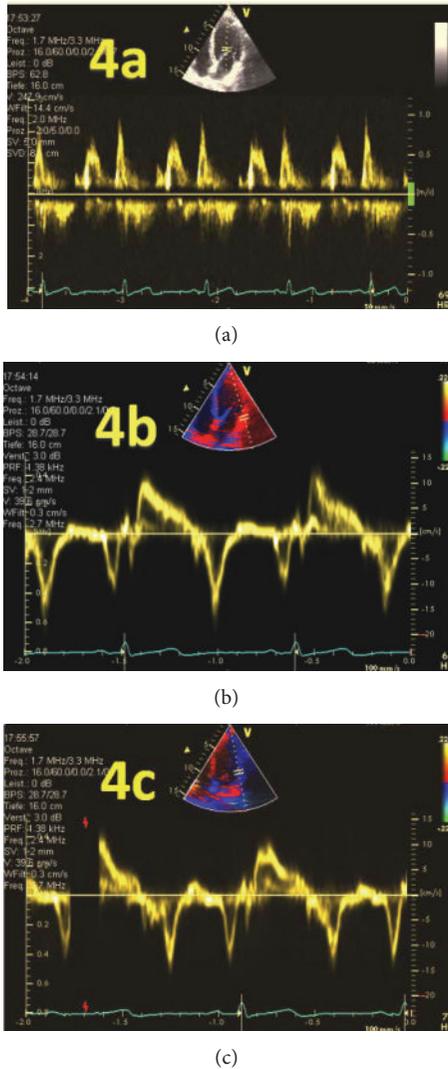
Pitfalls of the E/A and E/E' ratio measured using PW-Doppler and TDI. Different values for diastolic dysfunction when measurements are performed using (a) PW-Doppler; (b) TDI measurement of lateral mitral valve annulus motion; (c) TDI measurement moved light to the lateral LV wall.
